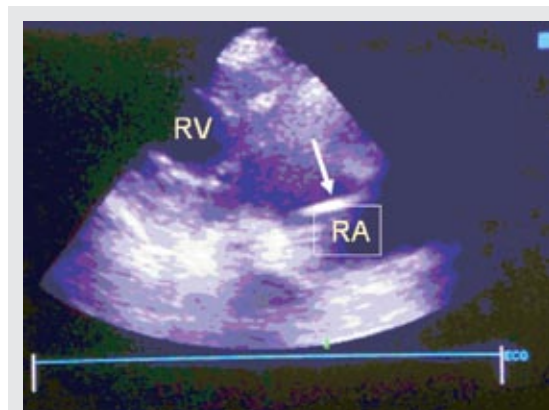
This is a modified echocardiographic view showing the radio-opaque catheter tip protruding into the posterior aspect of the right atrium. The arrow points to the tip of the catheter fragment.
